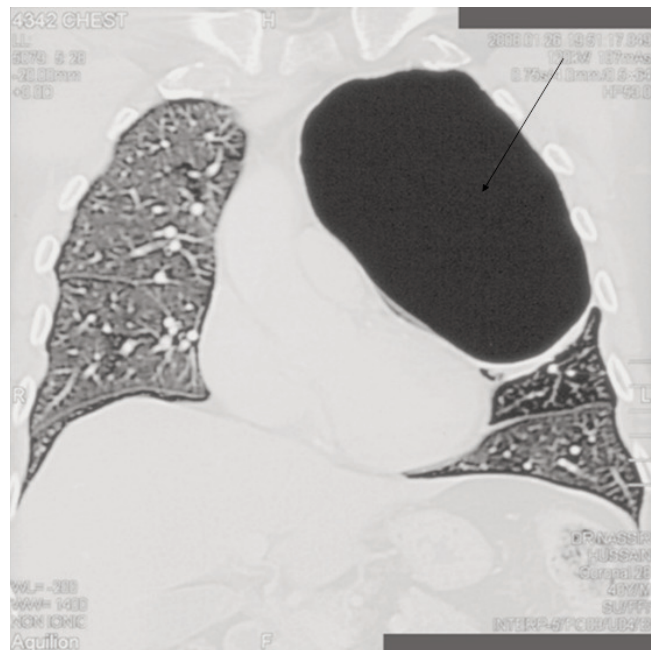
CT scan chest. Know depicting the bulla.
